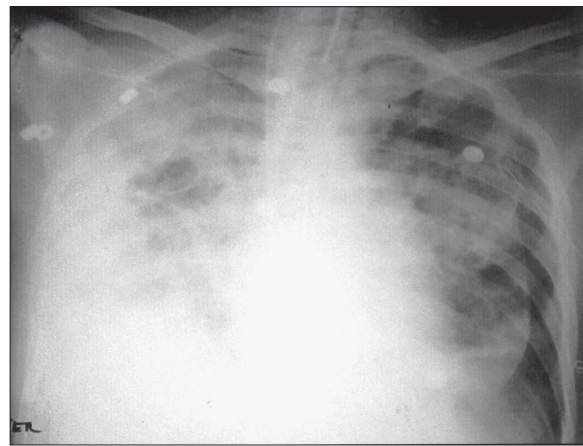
Chest radiograph showing left sided pneumothorax.
